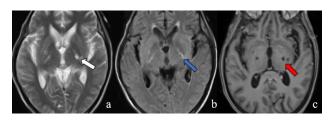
CNS cryptococcoma; axial T2 weighted (a), FLAIR; (b) T1 post contrast; (c) MRI showing few lesions in bilateral lentiform and caudate nuclei appearing hyperintense on T2WI (white arrows) and showing incomplete suppression on FLAIR (blue arrow); on post contrast study, few lesions show subtle peripheral enhancement.²²
